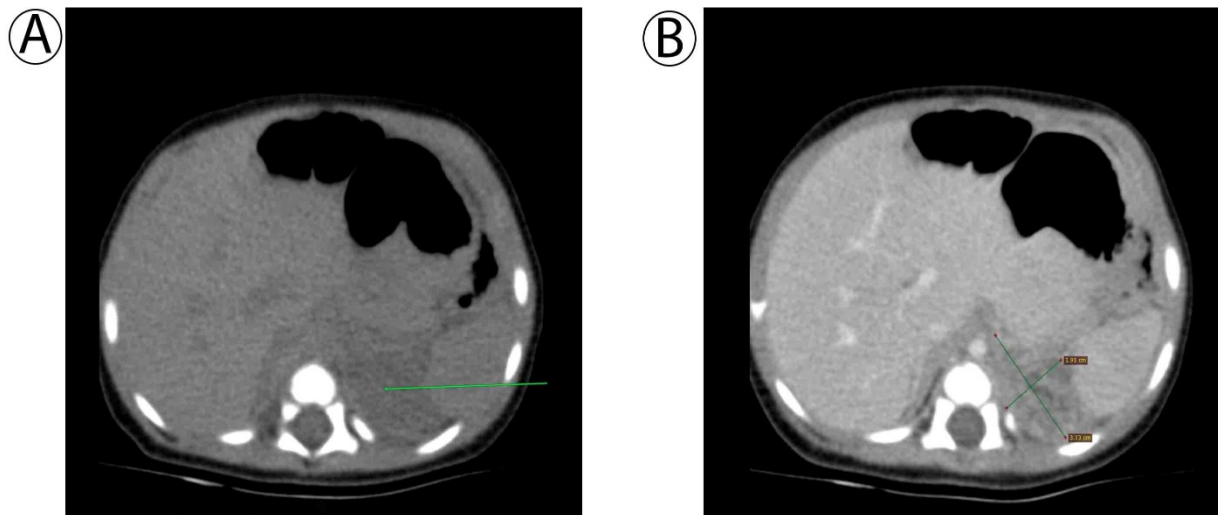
CT scan (A pre, B post contrast) show left side retroperitoneal mass above left kidney, beneath left crura. Homogeneous density of 31x29x19 mm (AP xCC xRL). Showing inhomogeneous enhancement with contrast by focal area of low fluid density
